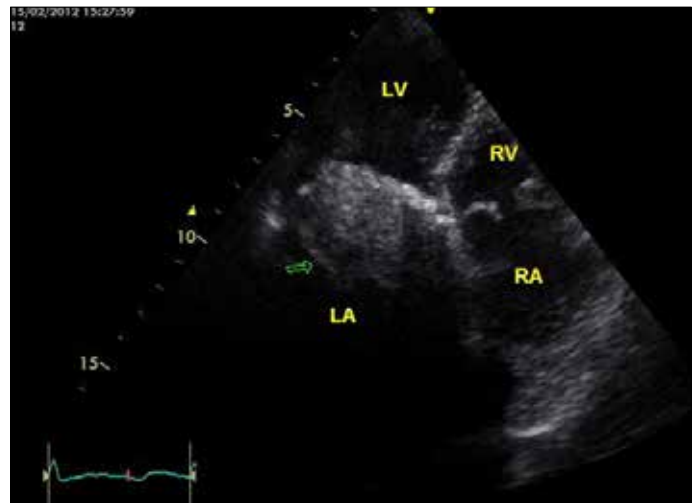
Apical four- chamber TTE shows huge calcific mass in the mitral valve
